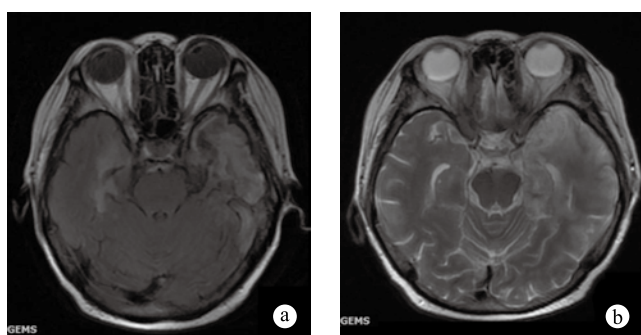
MRI scan: After one-month hormone shock therapy
